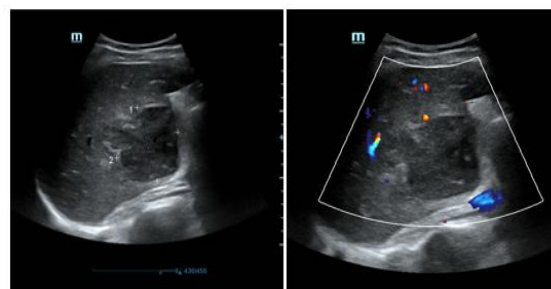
Gray Scale Ultrasound Showing well-defined thick-walled hypoechoic lesion in the right lobe of liver.
